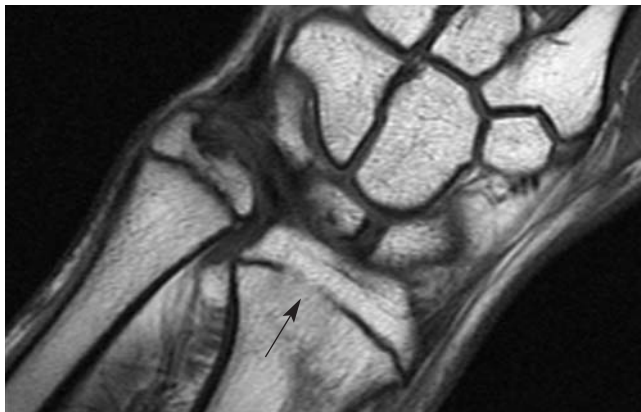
Physeal bar on MRI
